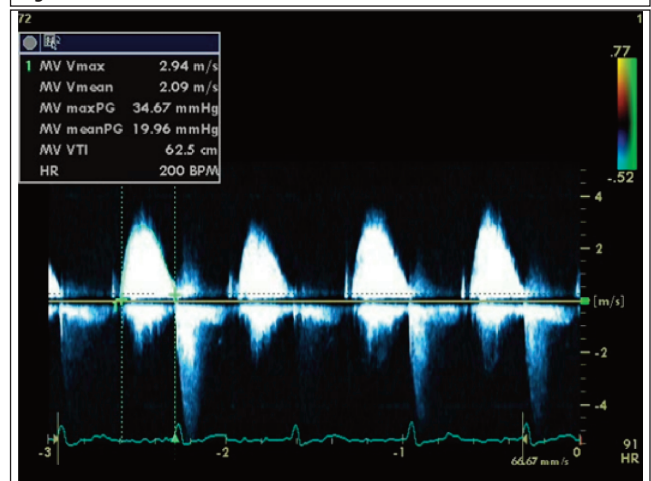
b: Elevated gradients across mitral valve on Doppler.
